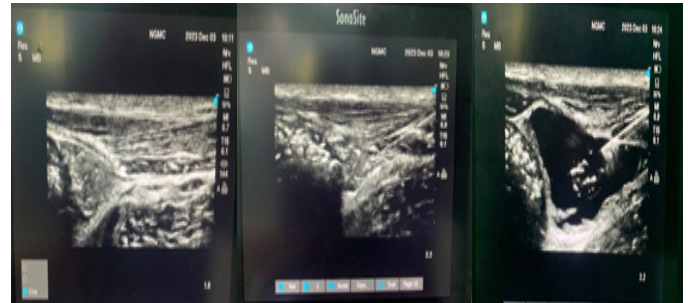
Ultrasound Image of front of the thigh at the level of groin crease, demonstrating the landmark, injection and drug deposition for FICB
